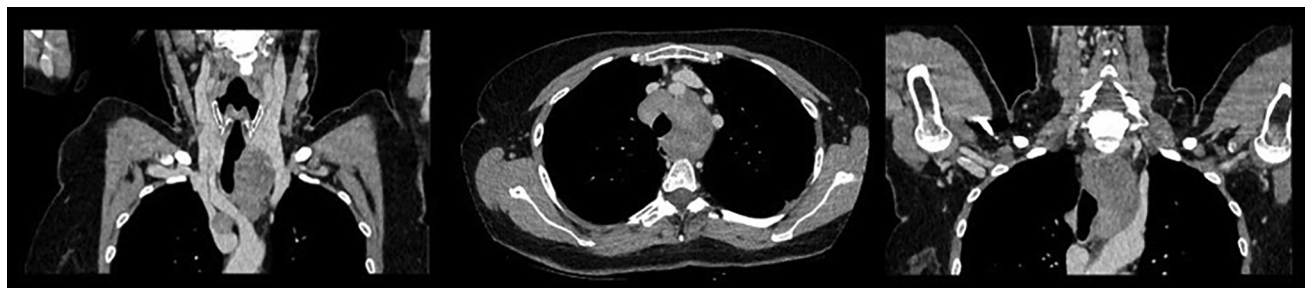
Shown is a large ACC invading the entire trachea, computed tomography scan (coronal and axial planes). ACC, Adenoid cystic carcinoma.
